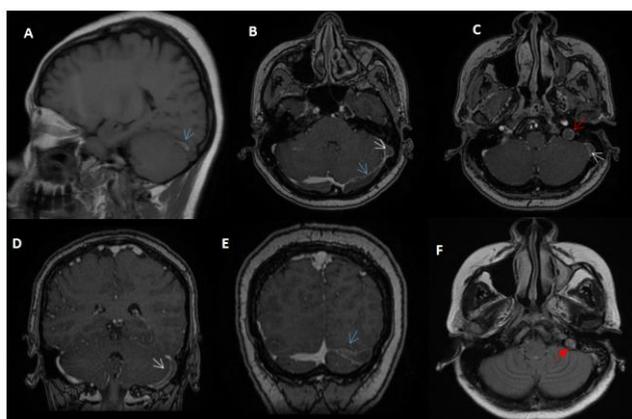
Brain MRI with gadolinium.
